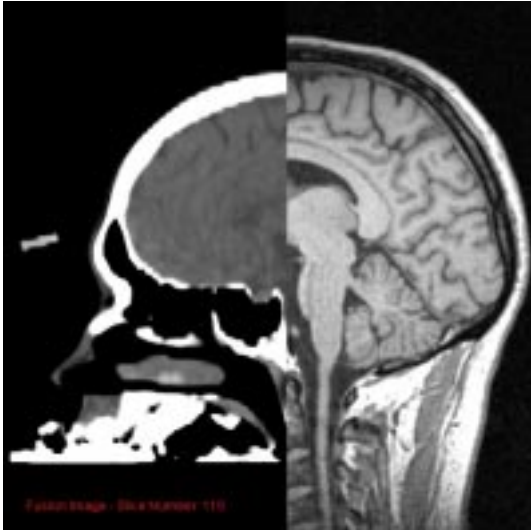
2D example of a sagittal CT-MRI fusion image before (the upper image) and after registration (the lower image); (CT - the left part /windowed for highlighting inner structures of the brain/, MRI - the right part)
